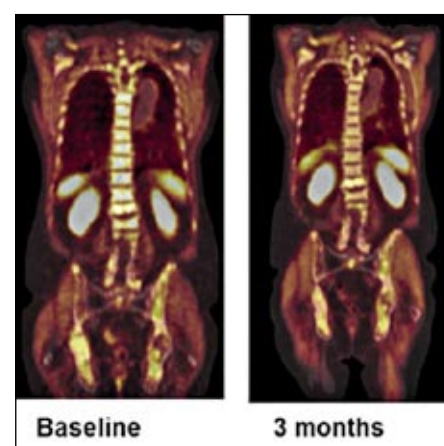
PET-CT images of a patient with metastasized prostate cancer who was enrolled in a phase I trial at the Early Clinical Trial Unit of the CCC MF.
